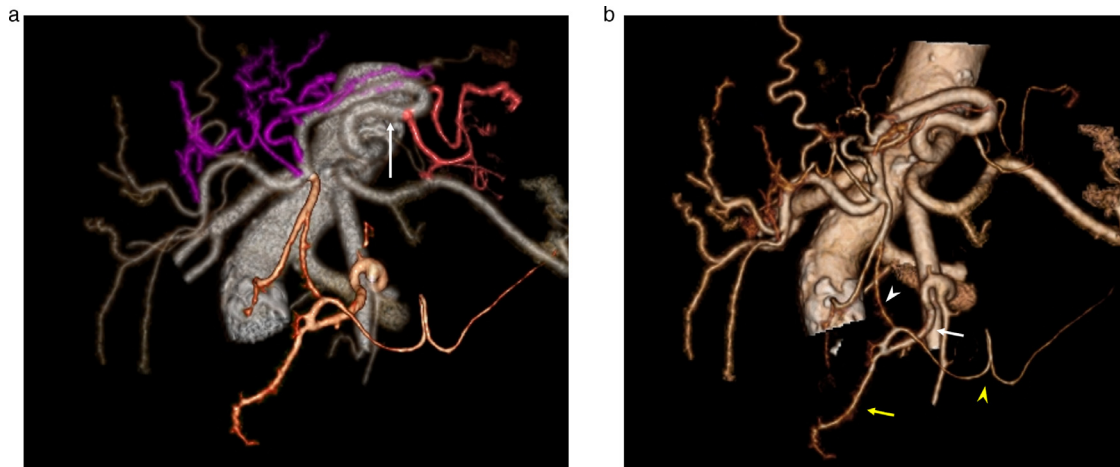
Abdominal contrast-enhanced computed tomography (CT) findings. (a) The common hepatic artery (CHA; white arrow) meandering in the lesser omentum without running on the superior border of the pancreas. Each feeding artery of segments II, III, and IV of the liver (purple color) branches from the CHA, not as the left hepatic artery (LHA). The left gastric artery (LGA; red color) originates from the CHA. (b) The developed inferior pancreaticoduodenal artery (IPDA; white arrow) continues to the anterior superior pancreaticoduodenal artery (ASPDA; yellow arrow). The right gastroepiploic artery (RGEA; yellow arrow head) branches from the IPDA and anastomoses with the gastroduodenal artery (GDA; white arrow head).
